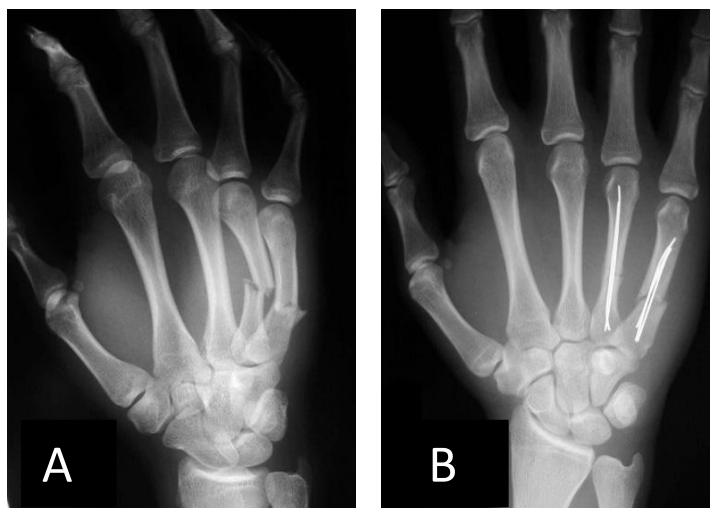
A; Oblique radiograph of right 4th and 5th metacarpal fractures. B; AP radiograph of 4th and 5th metacarpal fractures following close reduction and fixation with pinning. [21].
